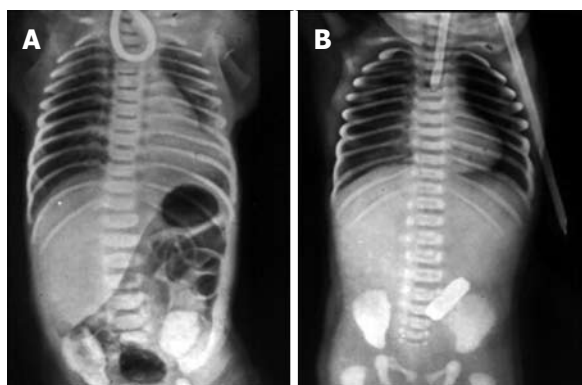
Plain X-rays of the chest and abdomen of two neonates with esophageal atresia. A: The non-progression of an orogastric catheter in the blind esophageal pouch and the presence of air in the stomach diagnose esophageal atresia with distal tracheoesophageal fistula; B: The radiopaque tube in the blind esophageal pouch and the absence of air in the stomach identify esophageal atresia without tracheoesophageal fistula.
